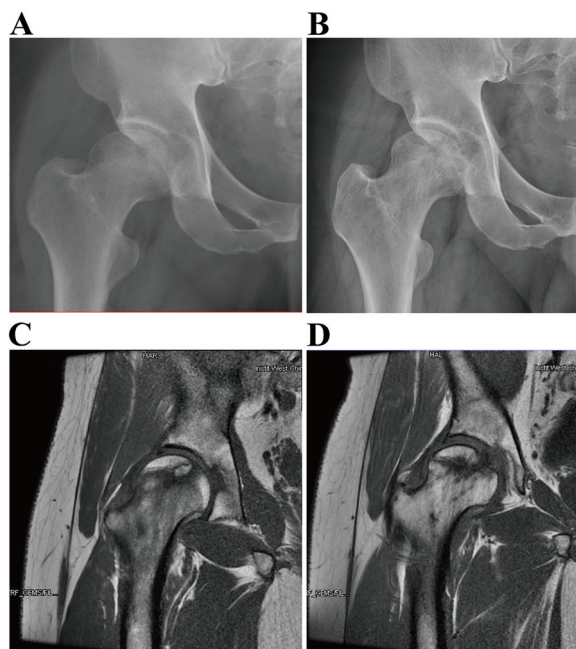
A, C Preoperative hip X-ray and MRI indicated ARCO II stage of femoral head necrosis. B, D X rays and magnetic resonance imaging at final follow-up of 12 months showing no significant progression of ONFH
